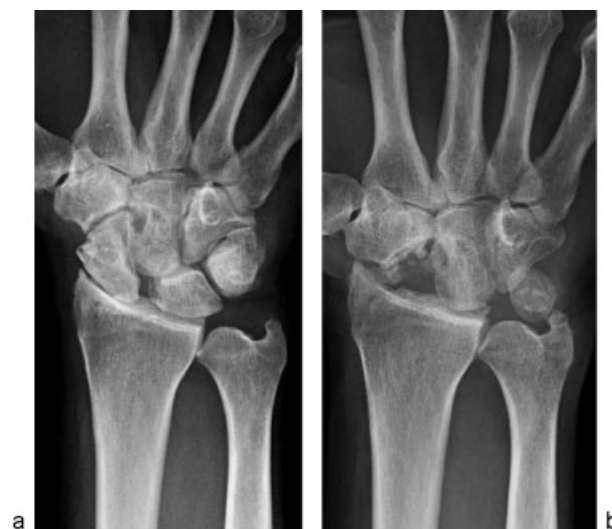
(a) Posteroanterior (PA) preoperative X-ray of a patient with SLAC wrist. (b) PA X-ray image 23.3 months postoperative after osteochondral grafting in PRC of the patient in Fig. 5a. This patient's degeneration was graded as none.
